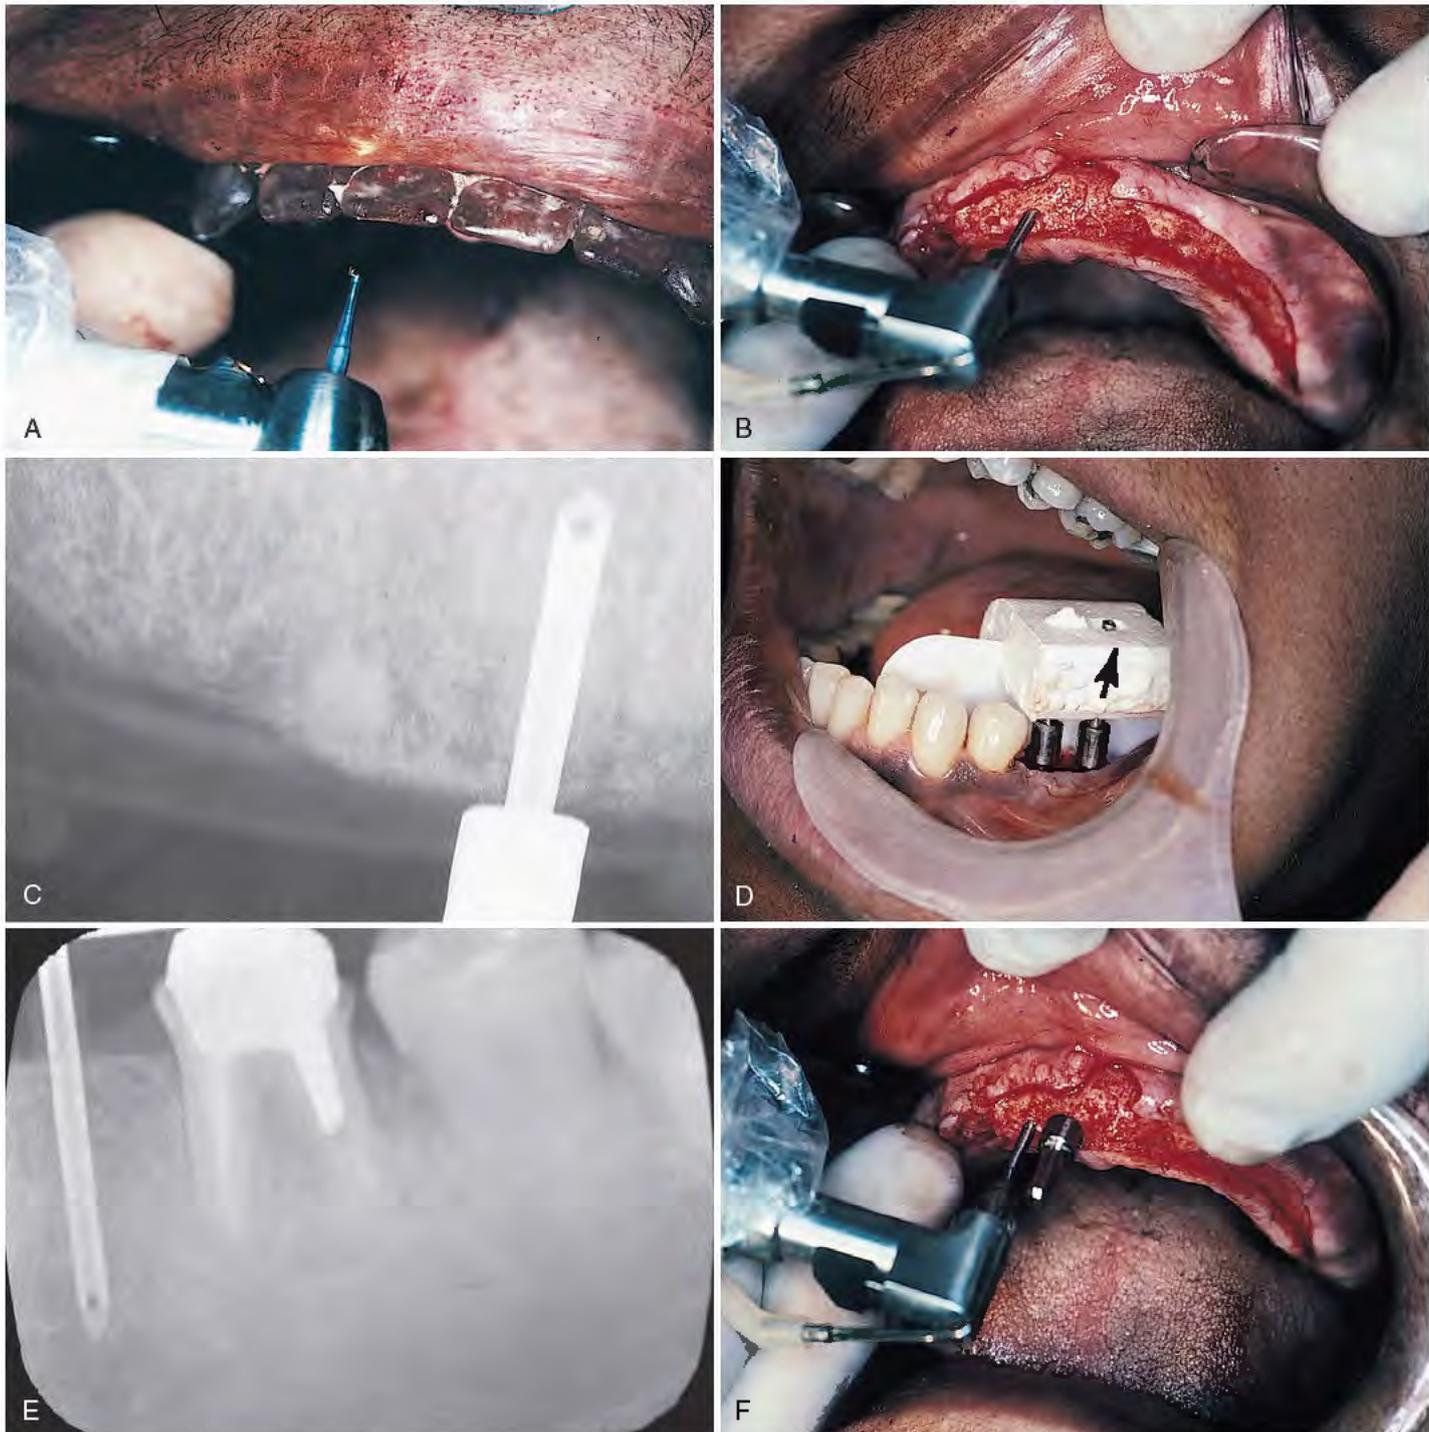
A, The surgical template is put in position. It both retracts the flaps and guides the placement of the starter osteotomy, just through the cortex. B, The second step is made with the 1.6-mm pilot drill, at the proper angulation and site, for distances of up to 11 mm. C, An intraoperative radiograph is taken to confirm the length and location of the pilot drill. D, Intraoperative radiographs are always used when nerves are near the host sites. A simple technique, which maintains sterility and keeps the patient's hand out of the field, involves a gas-sterilized Styrofoam film holder, which is held in position by paralleling pins or burs that pierce its soft block (*arrow*). E, The resulting film shows safe progress during the operation, as well as accuracy of distances, parallelism, and positioning. The first 1.6-mm diameter drill, if satisfactory, facilitates a simple, flawless operation. F, Pins are placed in each osteotomy to preserve continuing parallelism of adjacent bone cuts.
